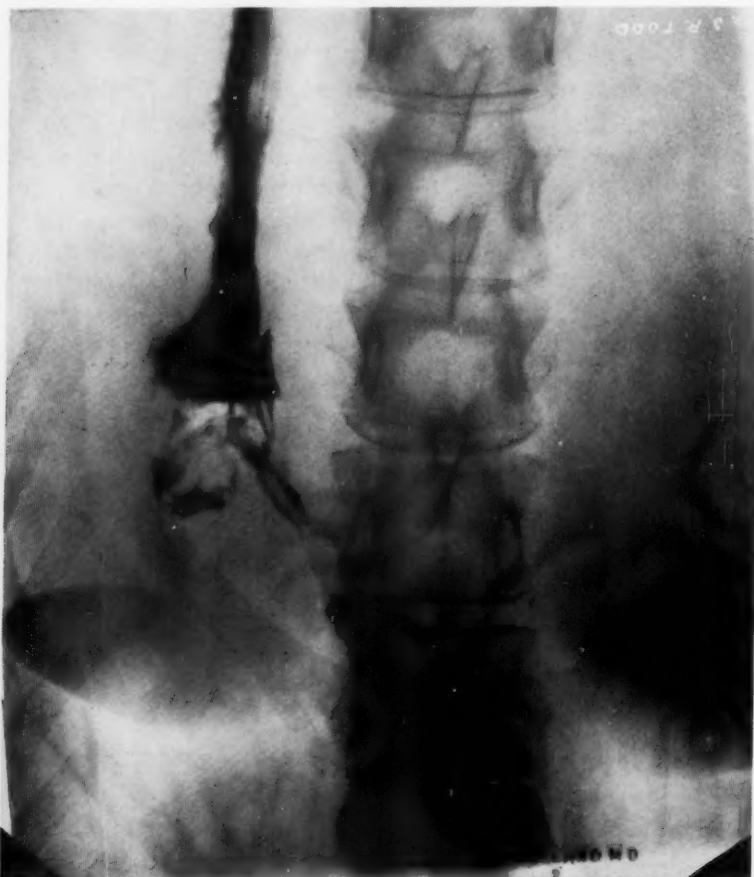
Roentgenogram showing slight dilatation of the lower esophagus with the greater amount of tumor tissue in the stomach just below the esophagus.
